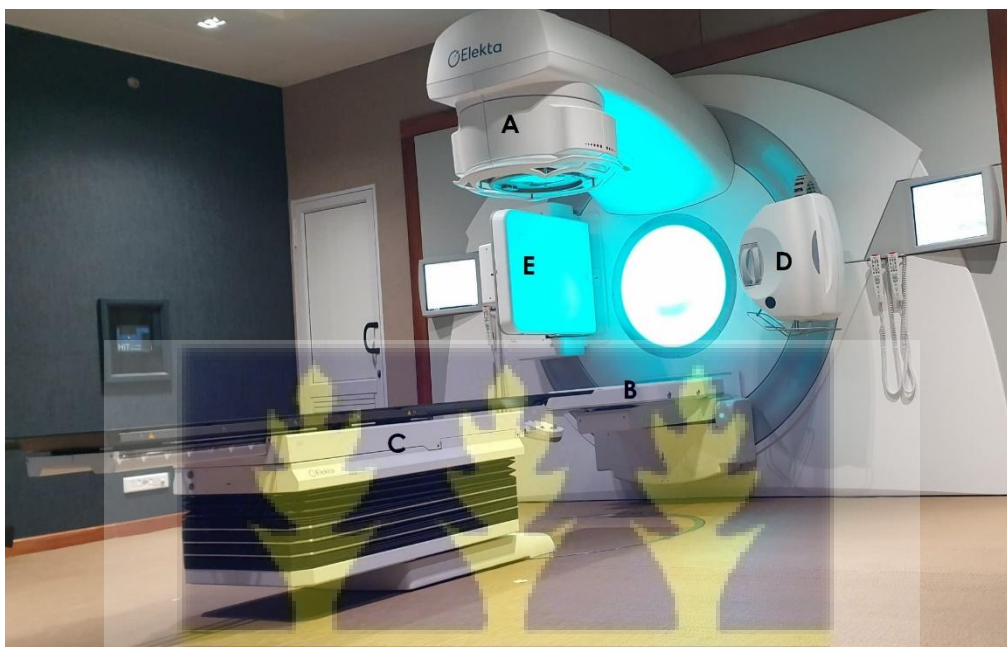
The Elekta Linear accelerator (LINAC) used in this study with various components; A is the LINAC head, B is the EPID detector panel, C is the treatment table, D is the CBCT system and E is the XVI detector panel.
